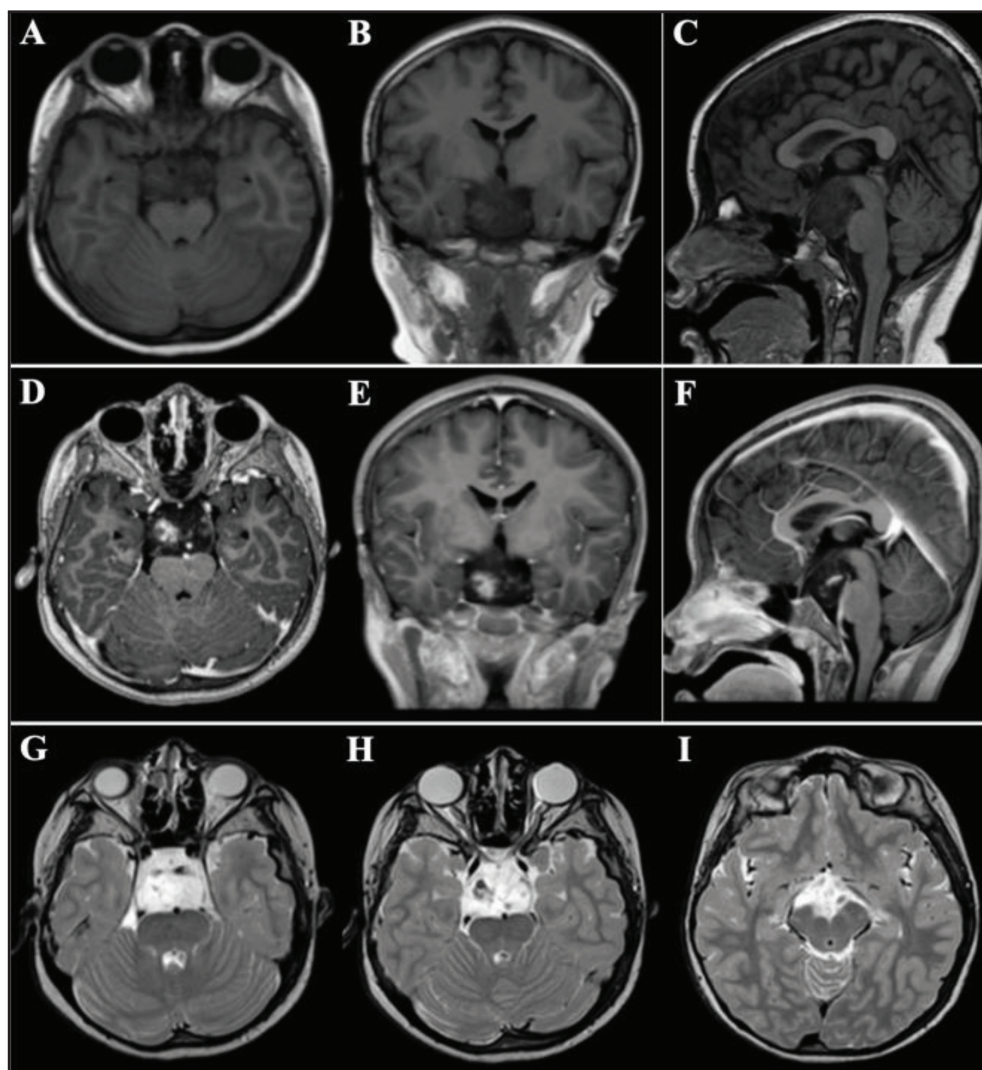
Pre-treatment MRI of Case 2. T1-weighted MRI without contrast in axial (A), coronal (B), and sagittal (C) views; T1-weighted MRI with contrast in axial (D), coronal (E), and sagittal (F) views; and T2-weighted MRI in axial (G), coronal (H), and sagittal (I) views. MRI demonstrates a large HH (Delalande type III) extending from the tuber cinereum into the hypothalamus, measuring approximately $2.7 \times 3.4 \times 3.0$ cm. The lesion is associated with mass effect on the midbrain, pons, optic chiasm, and third ventricle, and shows proximity to major intracranial vessels.
